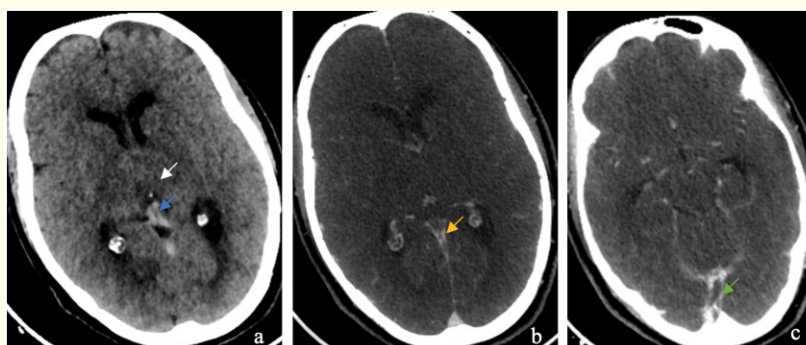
Non contrast enhanced brain CT (a) and contrast enhanced CT (c) in axial planes show bithalamic paramedian hypodensity (white arrow) internal cerebral veins that appear spontaneously hyperdense (blue arrow), with an heterogenous enhancement (yellow arrow) extending to the straight sinus (green arrow), correlated to a deep venous thrombosis.
